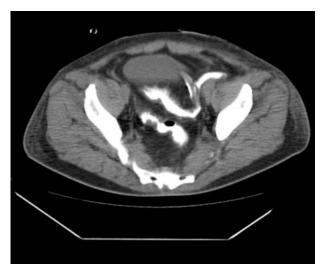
Post operative computed tomography image with rectal contrast showing skip lesion in rectum.
